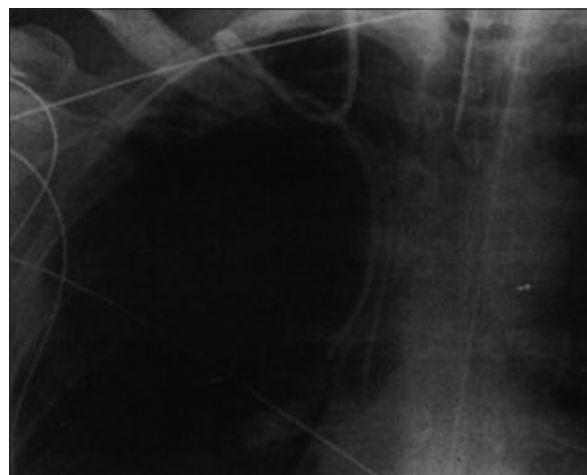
Catheter misplacement to the subclavian vein.^[39] Chest radiograph shows that the catheter is inserted via the right internal jugular vein and loops in the subclavian vein.
